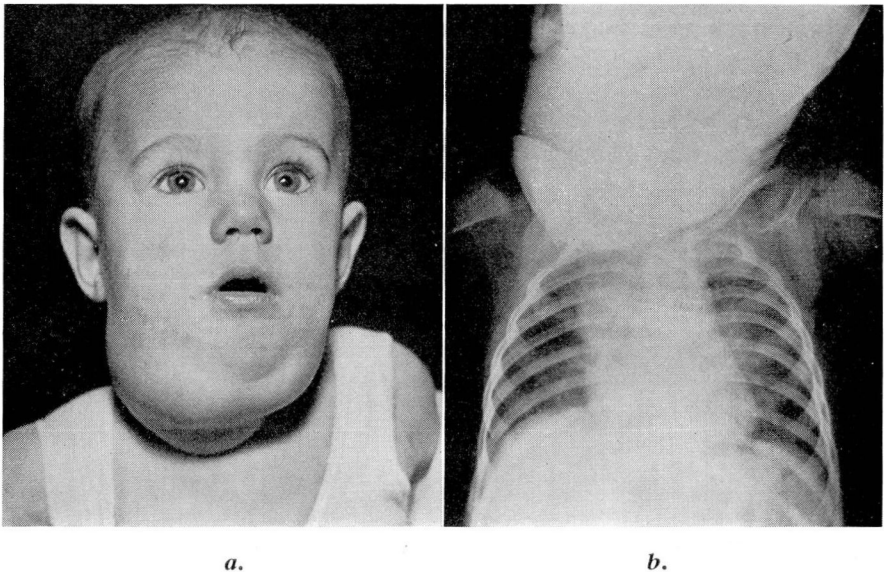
a. Photograph showing bilateral involvement of neck. b. Roentgenogram of chest showing involvement of mediastinum.
